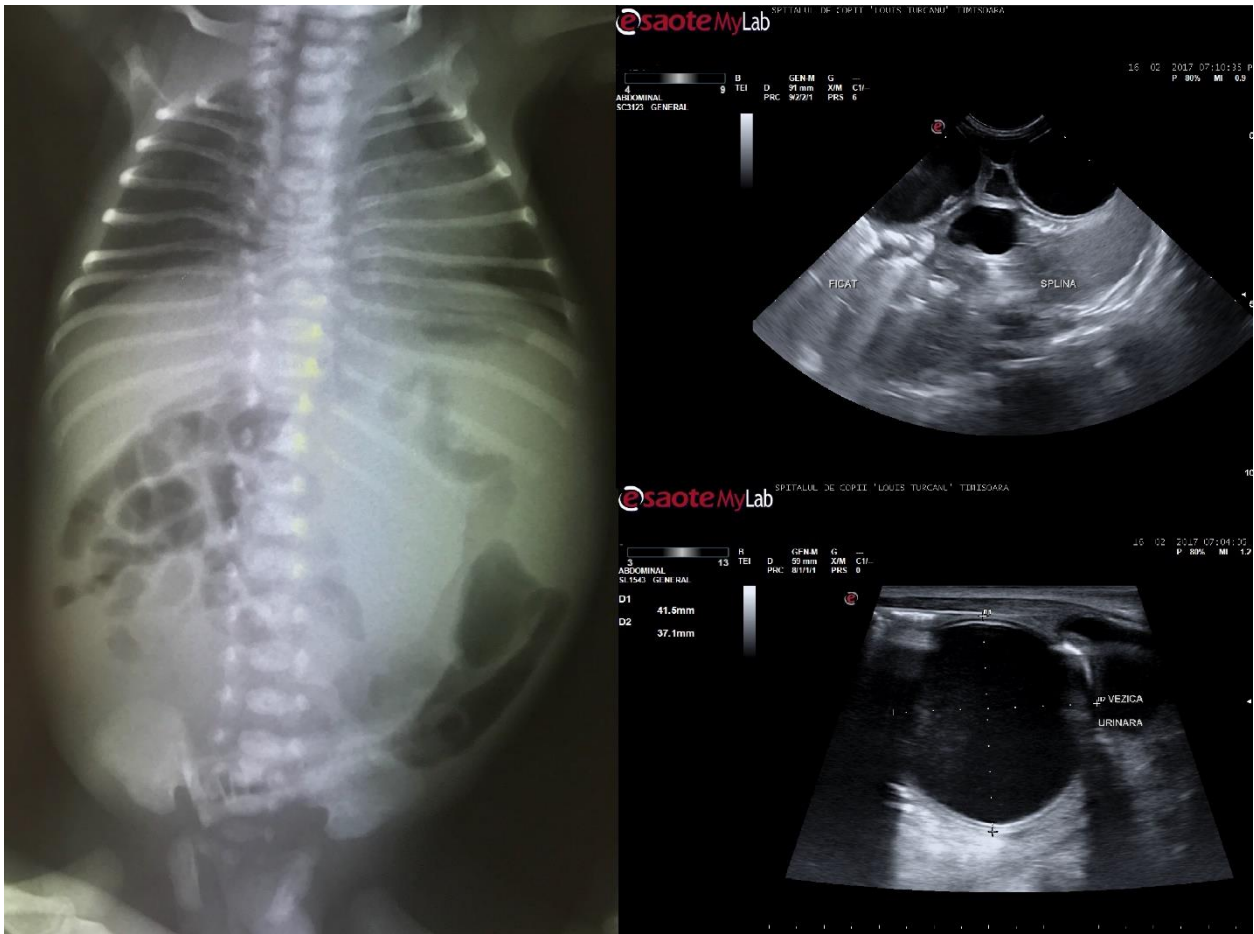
Plain Thoracic and Abdominal Radiography and Ultrasound images showing the characteristics of abdominal duplication cyst.
